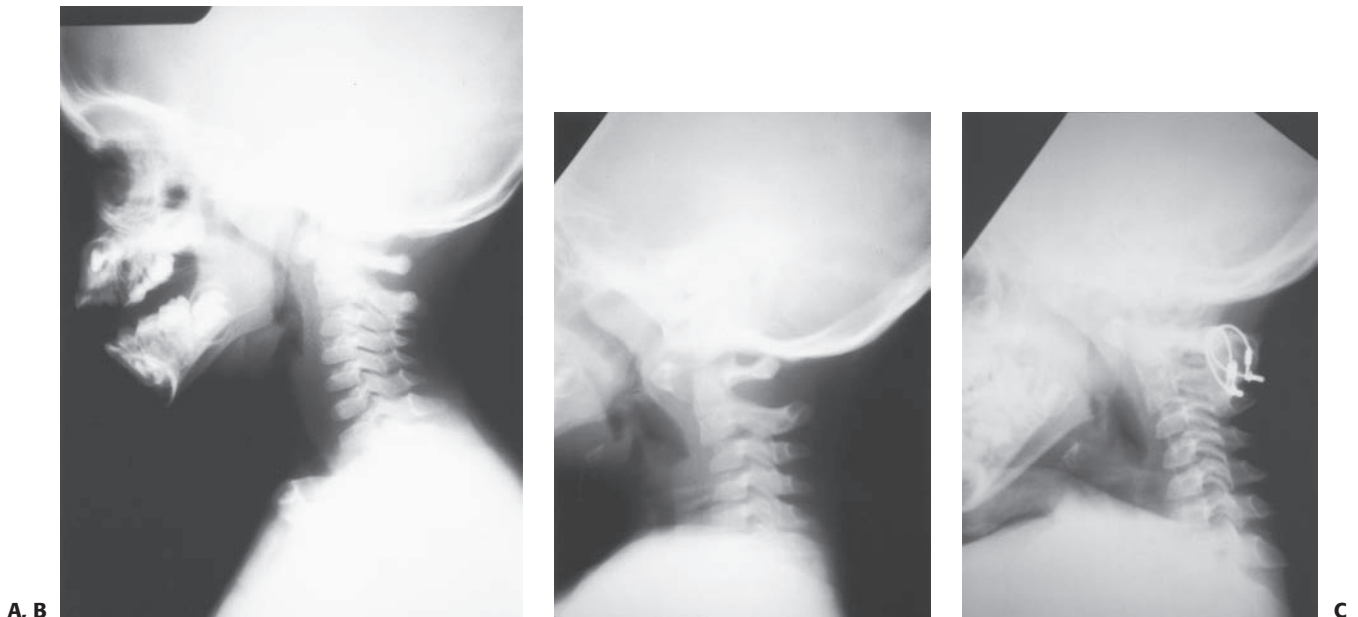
A: Lateral radiograph of traumatic C1 to C2 instability. B: Note the increase in the atlanto–dens interval. C: Lateral radiograph after C1 to C2 posterior arthrodesis.
